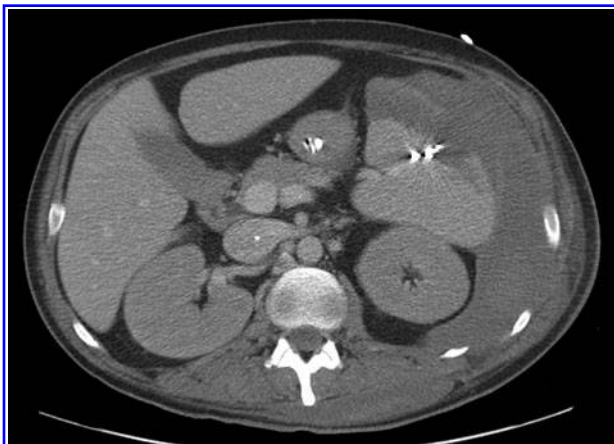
Computed tomography scan of abdomen documenting splenic rupture, hemoperitoneum, and angiographic coil embolization.
